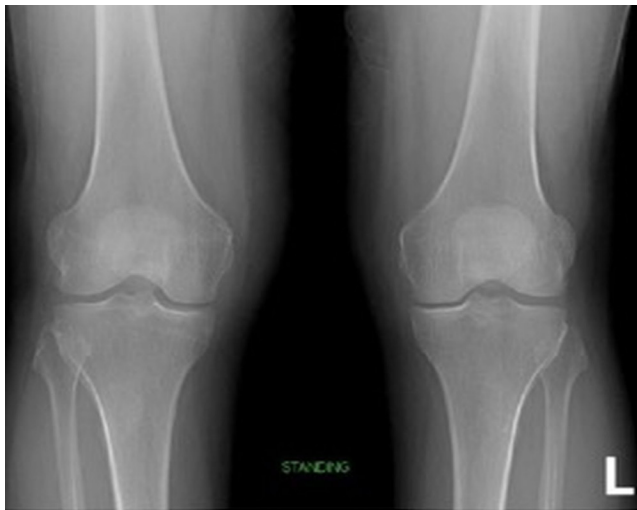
Preoperative standing radiograph showing mild arthritic changes of the knee joint.
